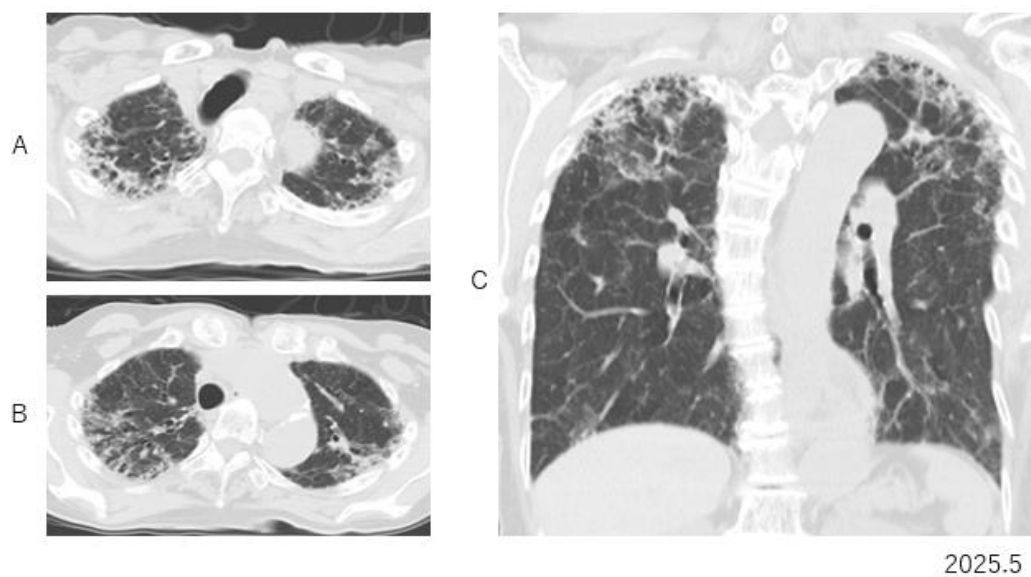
Four tears later, increasing in the degree of apical reticular pleural thickening is depicted on axial (A, B) and coronal CT (C).
